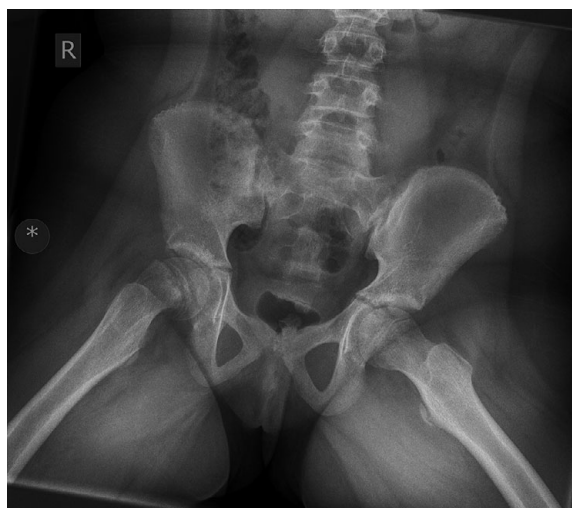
Anteroposterior (AP) radiograph of pelvis with frog leg lateral of both proximal femora
